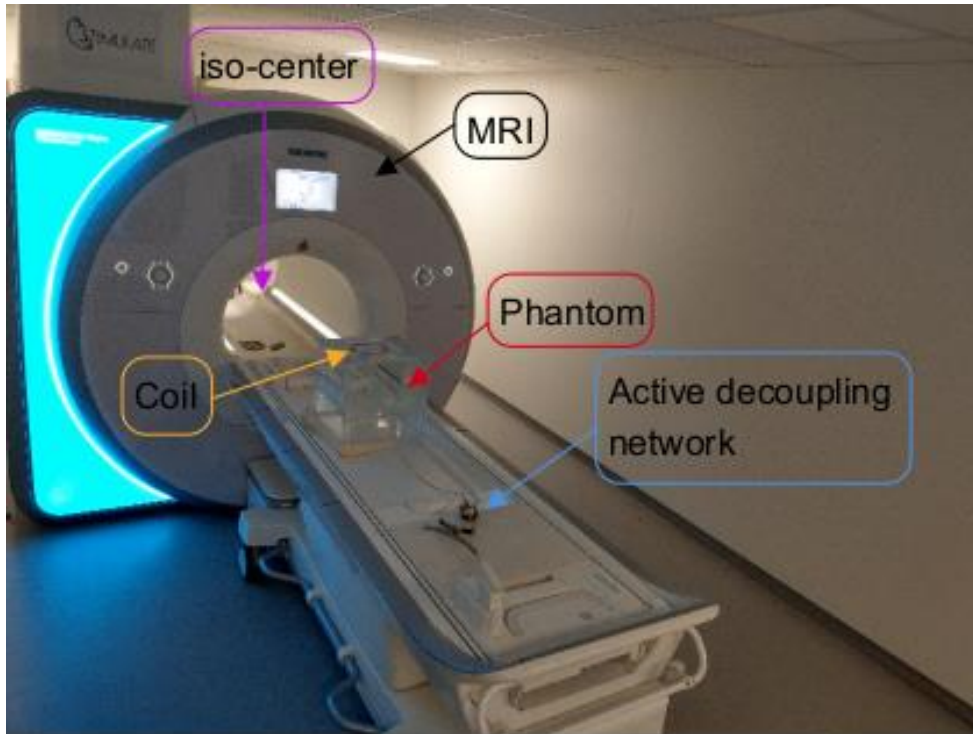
Measurement setup in the MRI.
